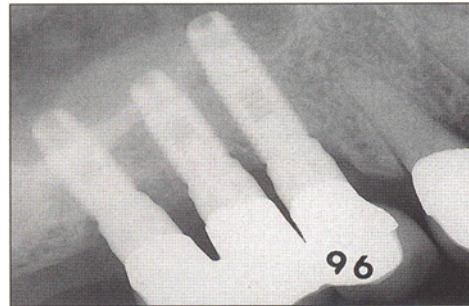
Two-year postloading radiograph.
